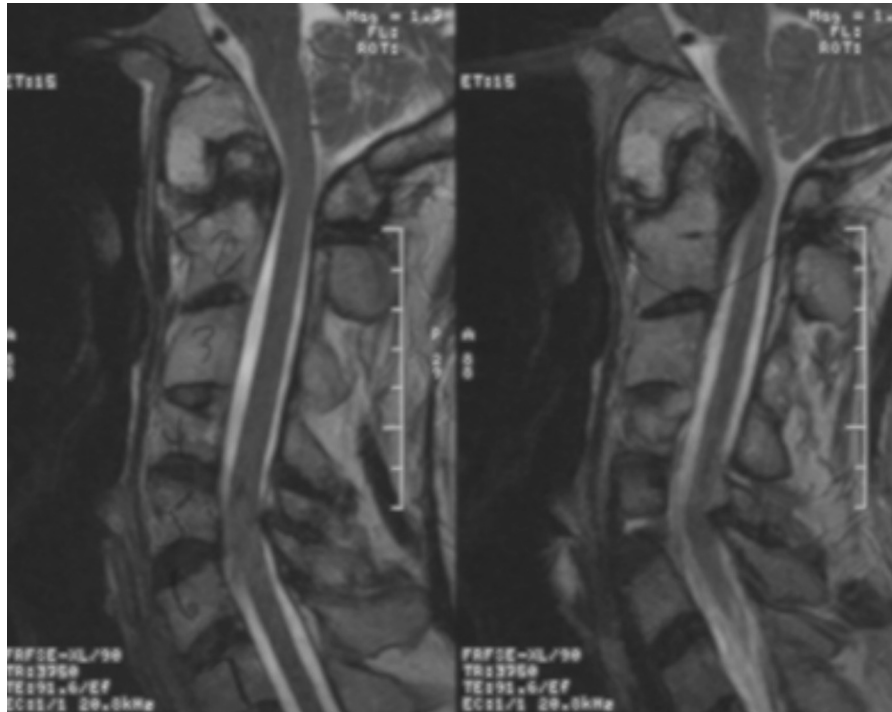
Sagittal T2-weighted magnetic resonance imaging sequence showing cord compression at the C5/C6 level.
